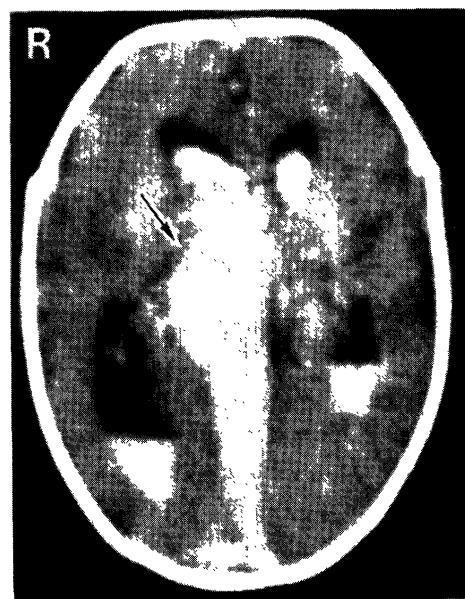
CT scan revealing a slightly high density midline structure (*arrow*) and intraventricular hemorrhage.
